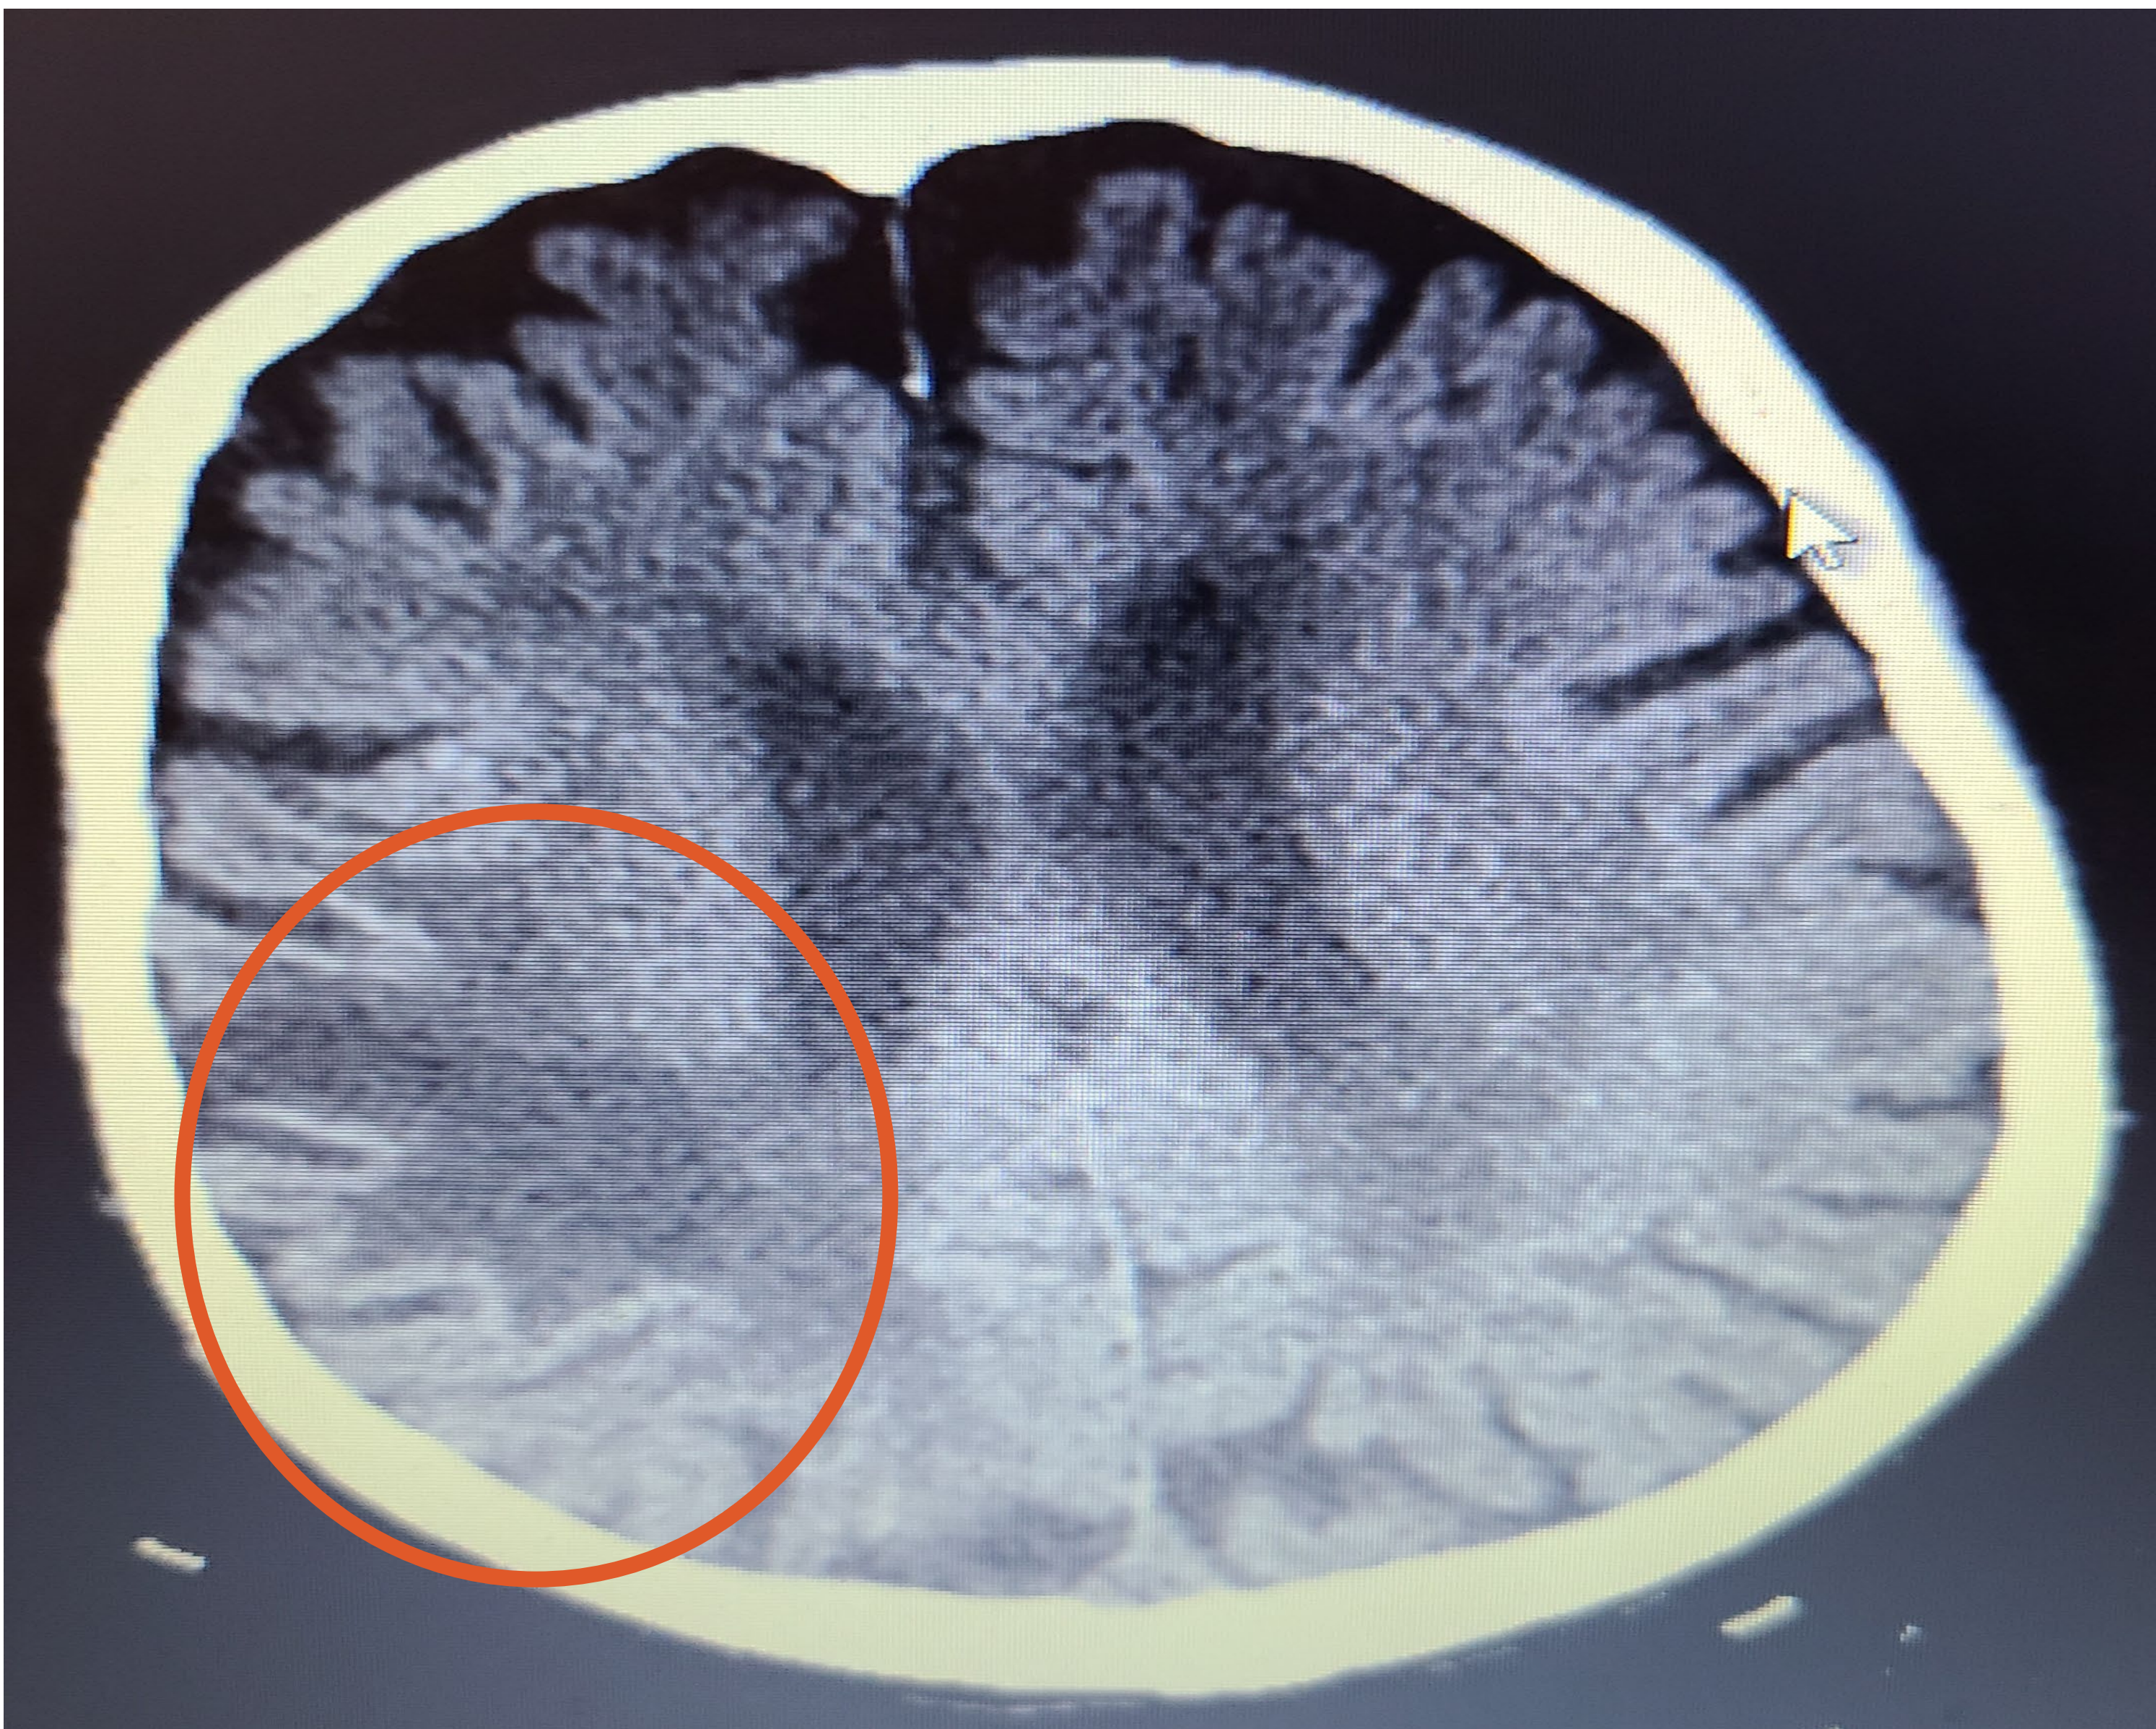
CT scan of the brain demonstrating hypodense area in the rt parietal area likely encephalomalacia (Old stroke)
